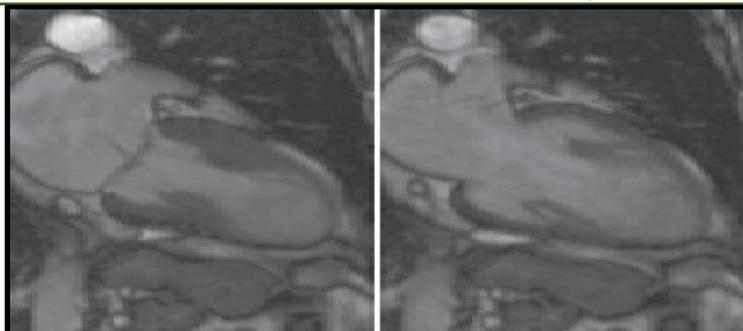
Appearance of Takotsubo on cardiac MRI
